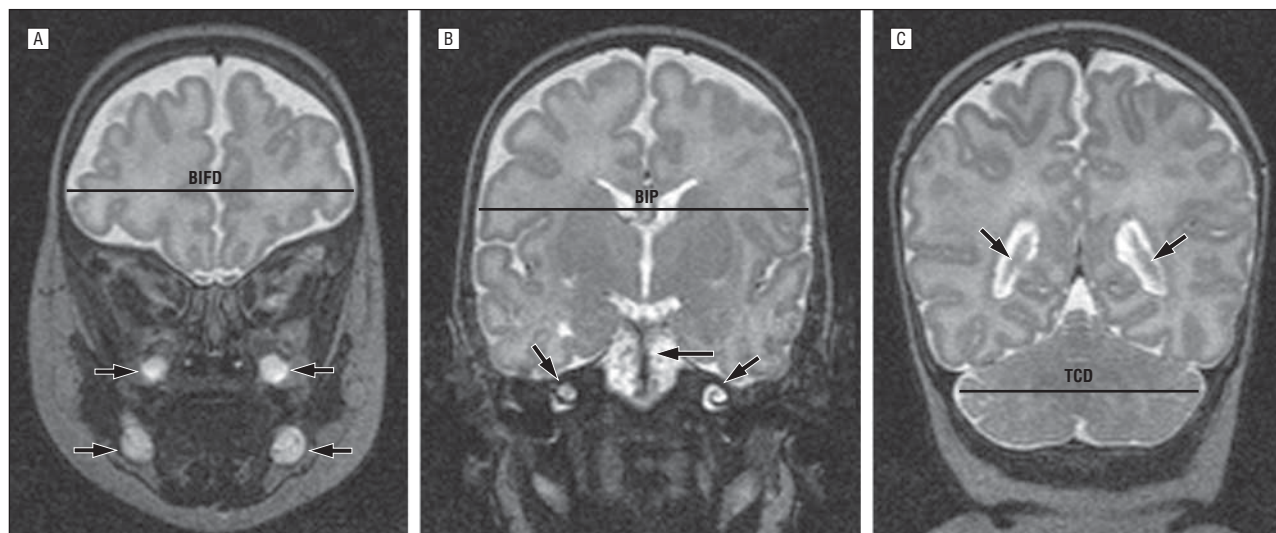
Landmarks (indicated by arrows) for brain metrics on magnetic resonance imaging. A, Bifrontal diameter (BIFD) (landmarks: teeth). B, Biparietal diameter (BIP) (landmarks: cochleas [left and right arrows] and basilar trunci [center arrow]). C, Transverse cerebellar diameter (TCD) (landmarks: posterior part of the lateral ventricle).
